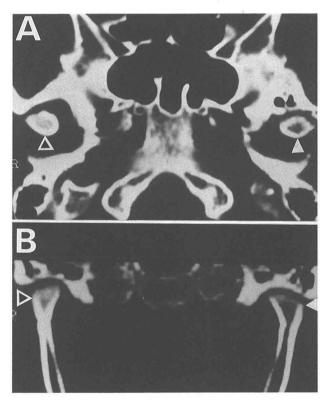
CT scans showing extremely flattened bilateral mandibular condyles. A, Axial CT scan disclosed sclerotic change of the right mandibular condyle (black triangle), and cortical osteolysis of the left condyle (white triangle). B, Coronal CT scan revealed sclerotic change of the right mandibular condyle (black triangle), and on the left side cortical osteolysis (white triangle) is seen.
